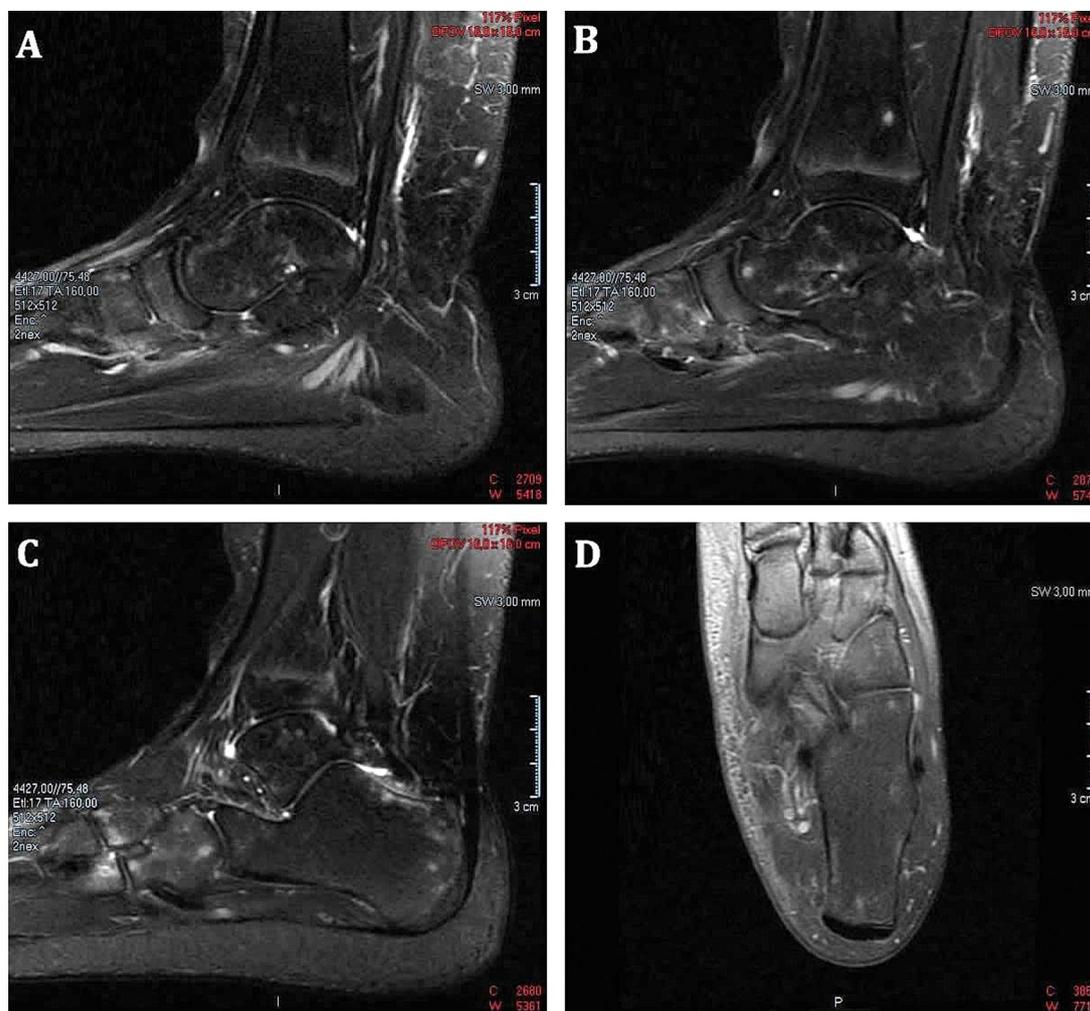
MRI scan (A–D) of the foot demonstrates diffuse hyperintensity in the tarsal bones and in the lower part of the tibia which is a sign of bone marrow oedema in T2 weight images.
